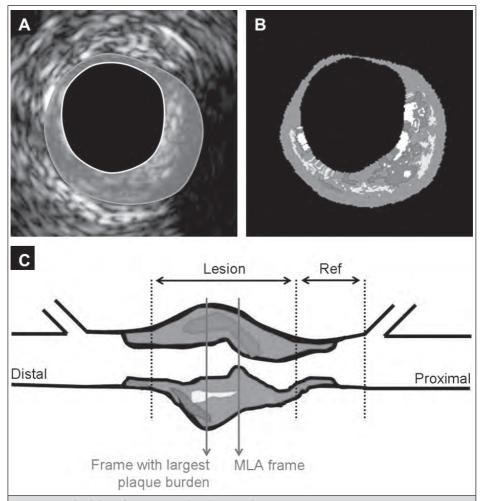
Methodology for intravascular ultrasound measurements
